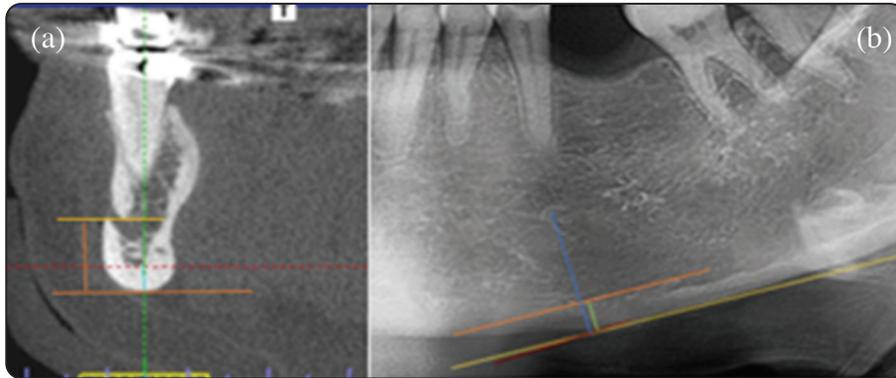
Measurement of Mental index.(a) CBCT cross sectional image showing (CTMI, CTI). (b) cropped panoramic image showing (MI, PMI).
